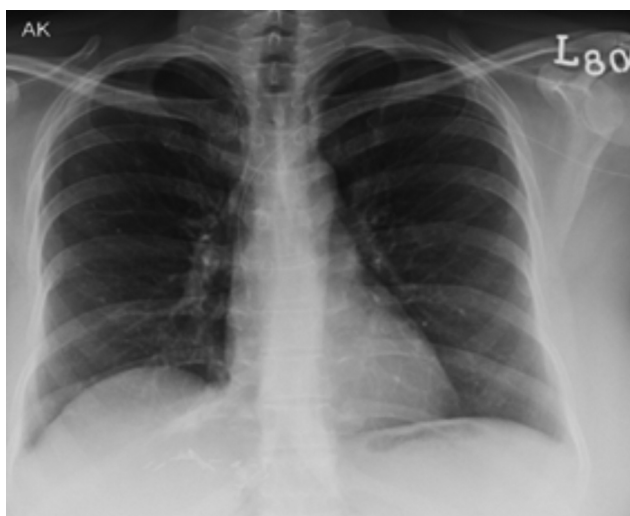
Three months old chest X-ray showing the PICC line in position (yellow arrows showing PICC location). PICC, peripherally inserted central catheter.
